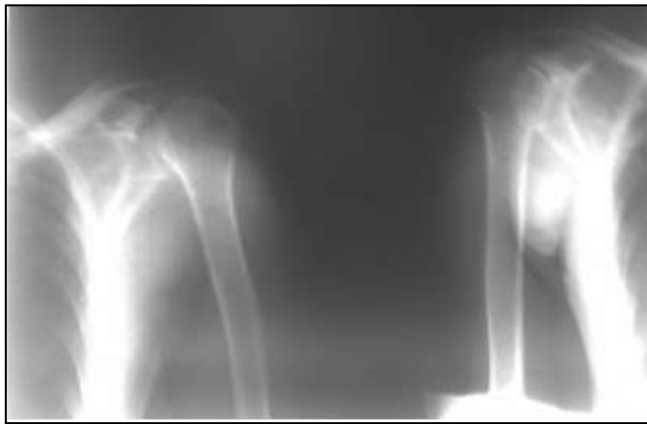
Post-reduction radiographs showing anatomical reduction of the greater tuberosity on both reduced shoulders
